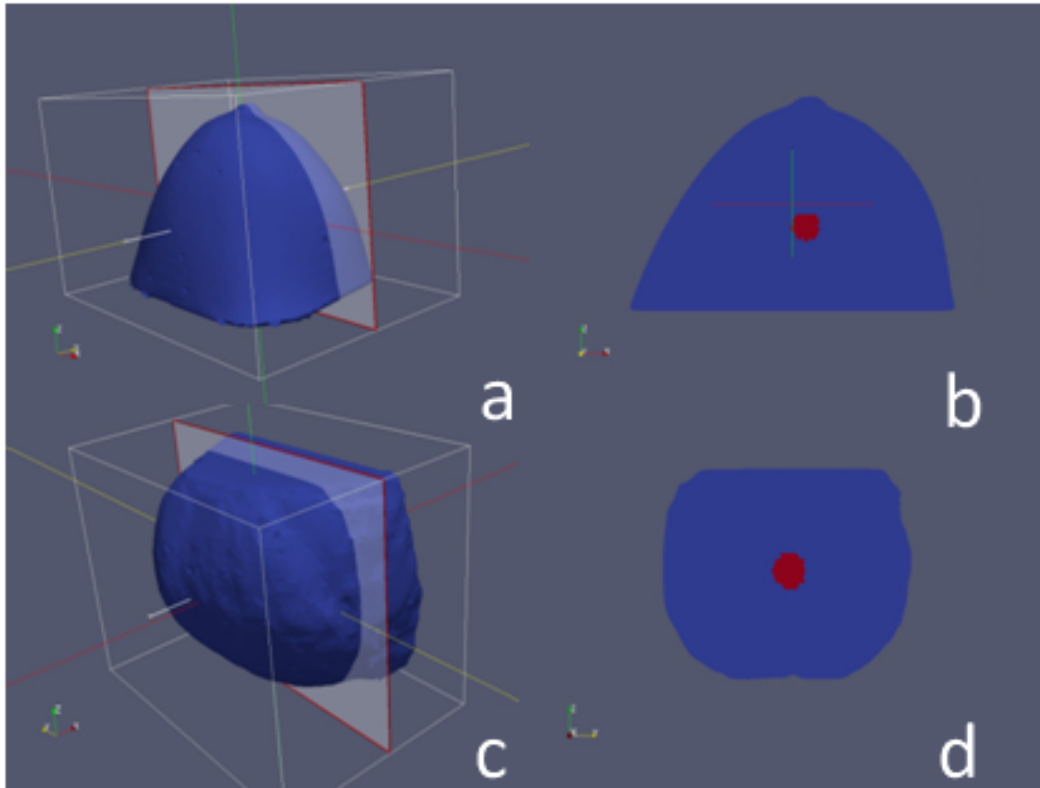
Example of MIE applied to a CT breast volume (a) with cross-section showing tumor-to-normal elasticity contrast (b), and an MR breast volume (c) with cross-section showing similar contrast (d). [215]
